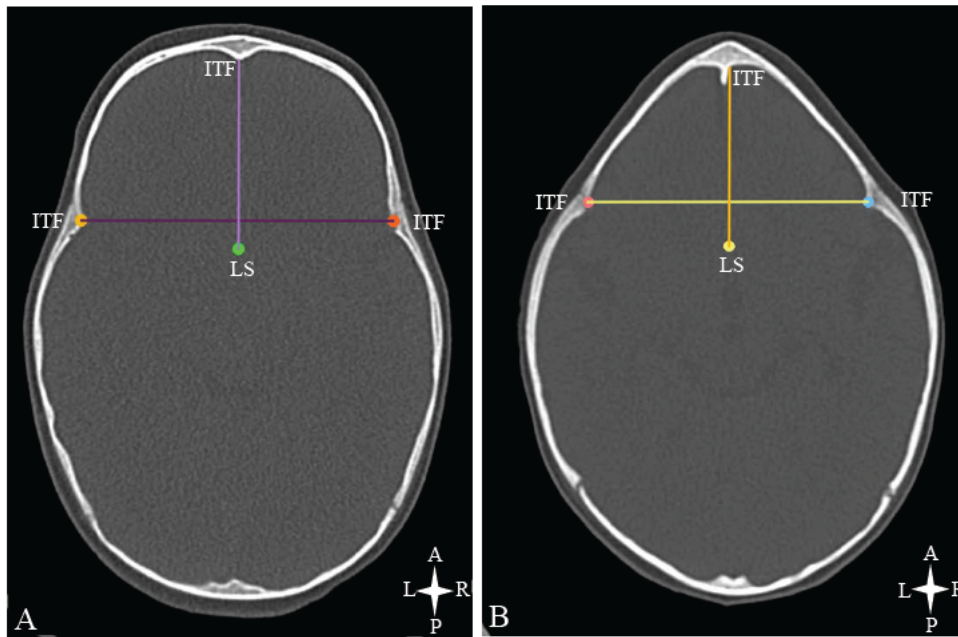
ACF length and width on an axial CT scan of a normal patient (A) and trigonocephaly patient (B) (length: LS to ITF; width: ITF to ITF). Key: LS – midpoint of limbus sphenoidale (extrapolated point); ITF – inner table of frontal bone
